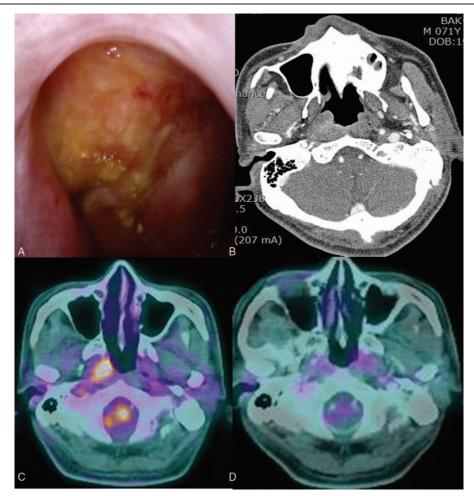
With carcinoma on the posterolateral wall of the nasopharynx, the nasal endoscopy revealed a protruded (A). The neck computed tomography image showed a mildly enhanced mass on posterolateral wall of the nasopharynx (B). Positron emission tomography scanning showed a hypermetabolic mass (C). No mass on the nasopharynx after chemoradiation therapy for carcinoma.
